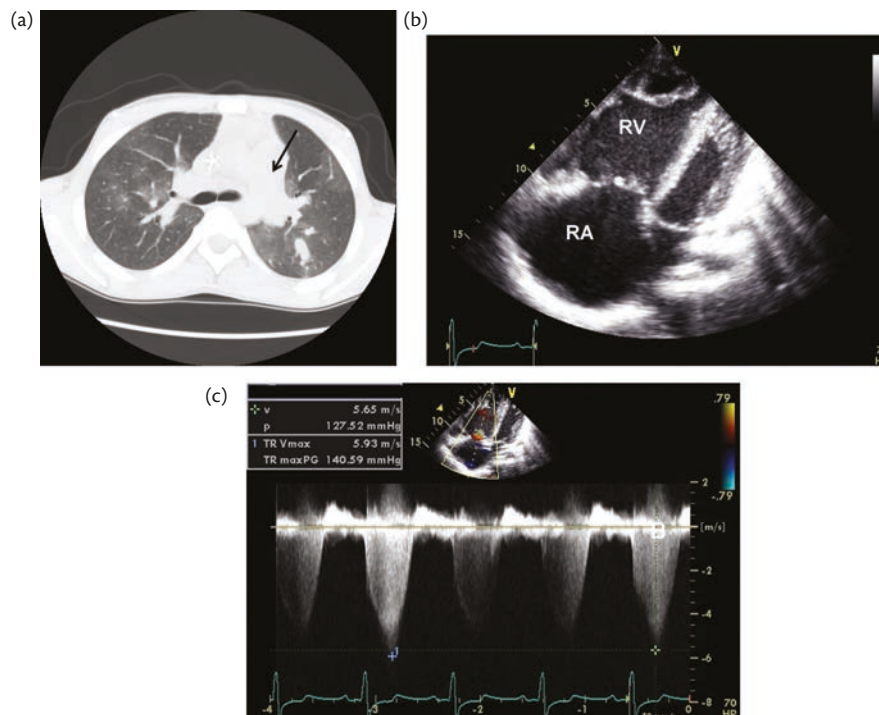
Patient with Sickle Cell Disease and Pulmonary Hypertension. (a) CT of the chest showing dilation of main pulmonary artery (black arrow) and mosaic perfusion in both lobes of the lungs. (b) A four-chamber view of the heart shows right ventricular (RV) and right atrial (RA) dilatation. Right ventricular wall thickness is increased consistent with right ventricular hypertrophy. There is flattening of the interventricular septum indicative of pulmonary hypertension. (c) A Doppler echocardiographic tracing shows peak tricuspid regurgitant-jet-velocity to be 5.9 m/second. With an assumed right atrial pressure of 15 mmHg, the estimated pulmonary artery systolic pressure is 154 mmHg. This constitutes severe pulmonary hypertension.
